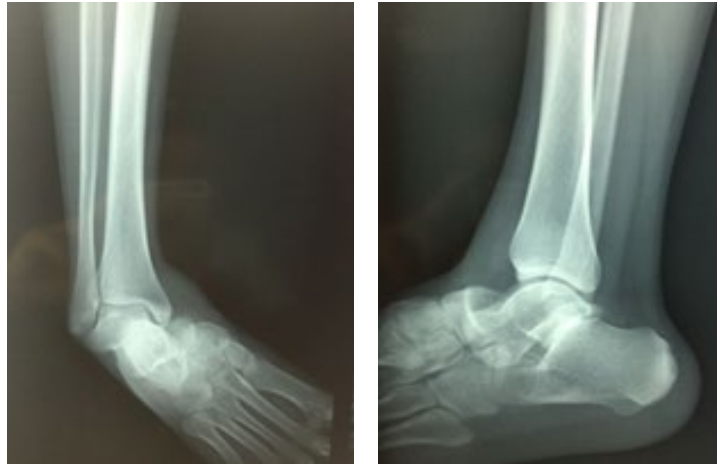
X-Ray, Front, and Side, Showing The Subtalar Medial Dislocation
